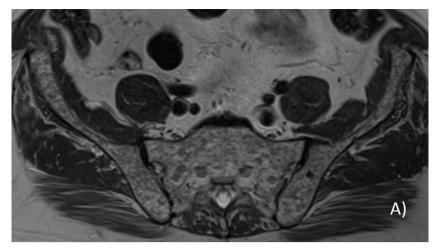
Example of diffuse bone marrow infiltration pattern. In A) an axial T1-weighted image showed diffuse bone marrow infiltration pattern, with a typical homogenous decrease of signal.
